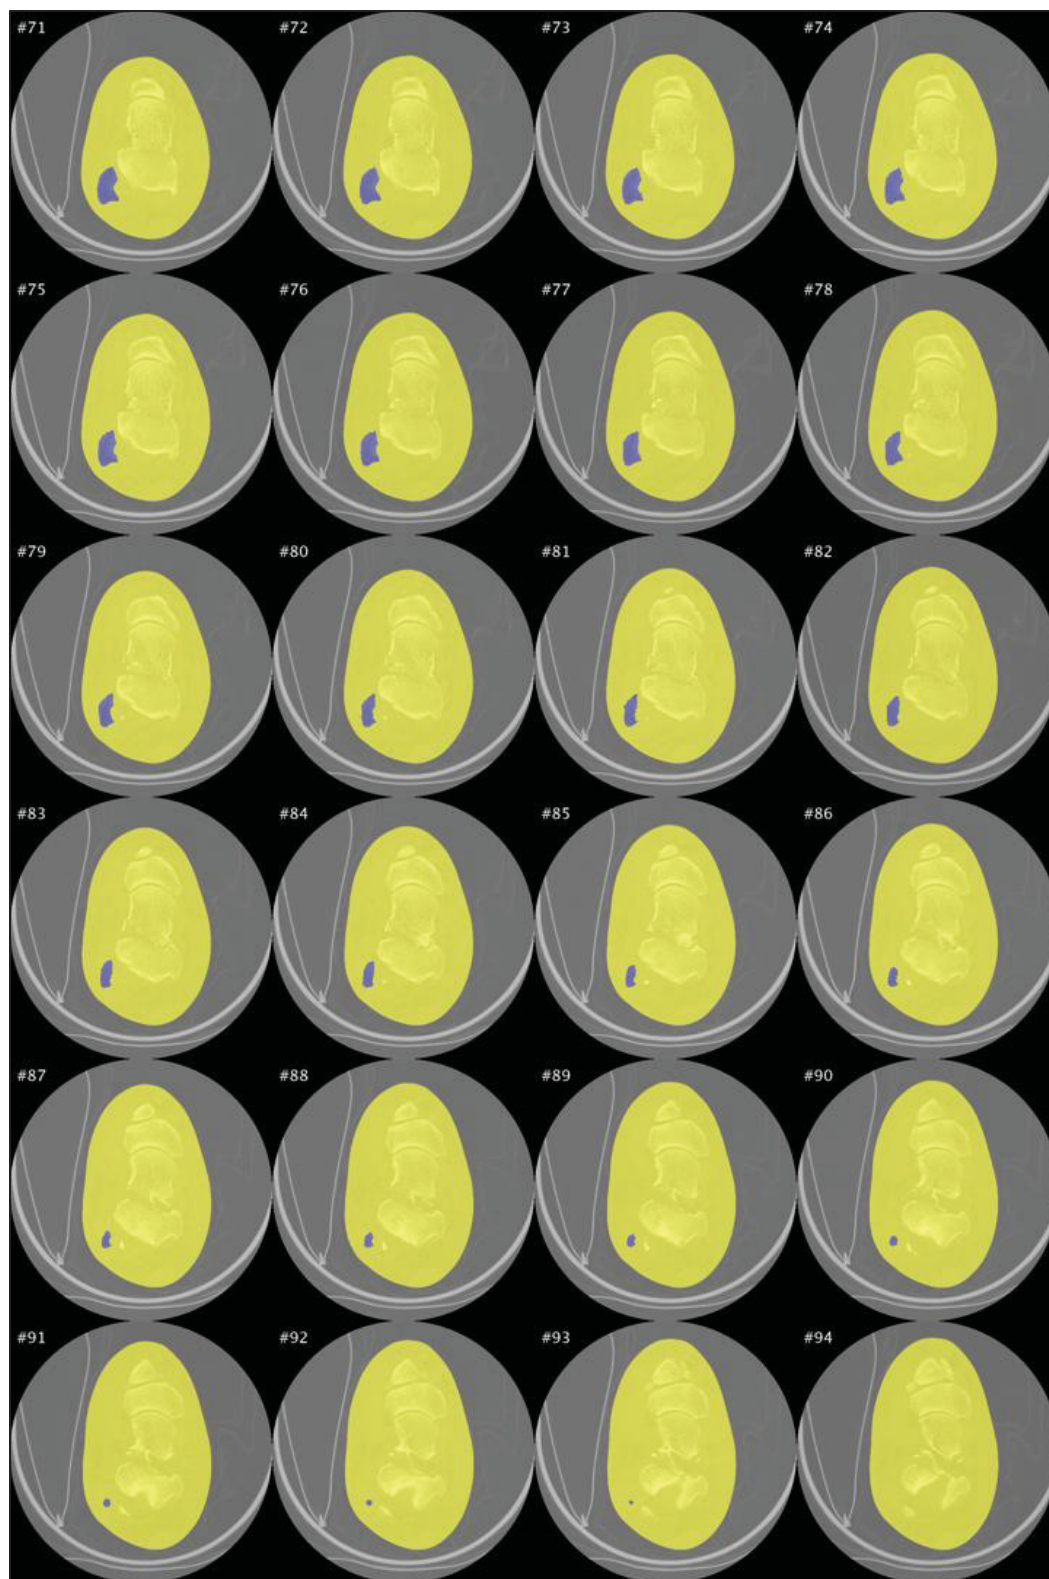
Figure-A I-2: Slice-by-slice segmentation for a CT-Scan sample, slice 71 to 94
